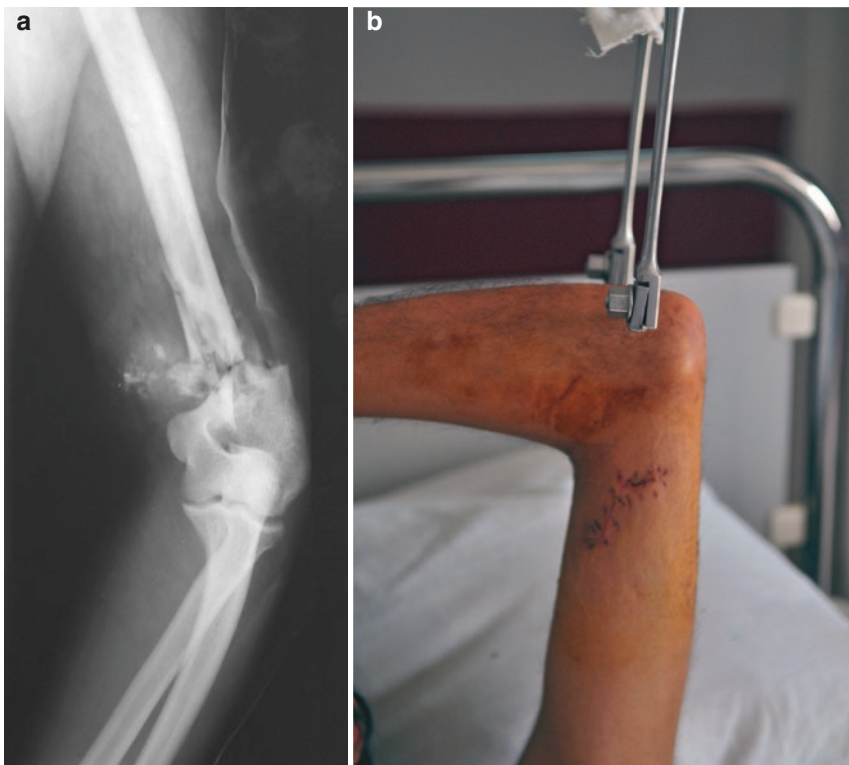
(a) X-ray of GSW with comminuted distal humerus fracture. (b) Trans-olecranon traction. (c, d) At around 2–3 weeks, the fracture is sticky enough to be immobilized in an above-elbow POP, which is applied
